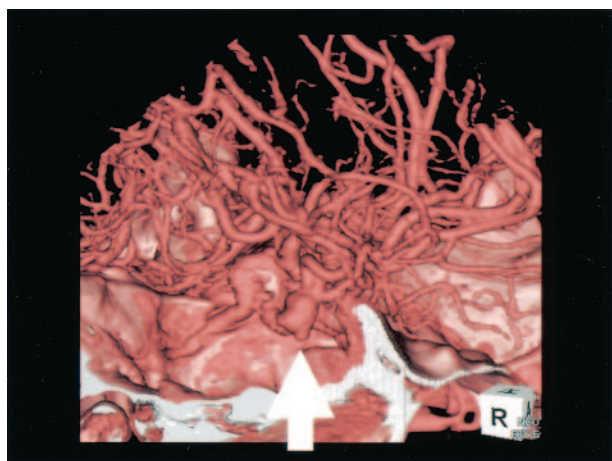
4D-CT angiography of intracranial aneurysm of the right MCA. A small protuberance from the bleb is seen during the period from 45% to 55% of the R-R interval (arrow).
